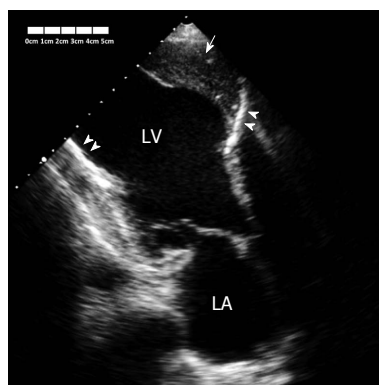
Transthoracic echocardiogram using apical three chamber view showing the big anterior left ventricular aneurysm (arrow). The wall of the aneurysm was calcified (arrowheads), and the aneurysm was covered with thrombus (arrow). LA: Left atrium; LV: Left ventricle.
